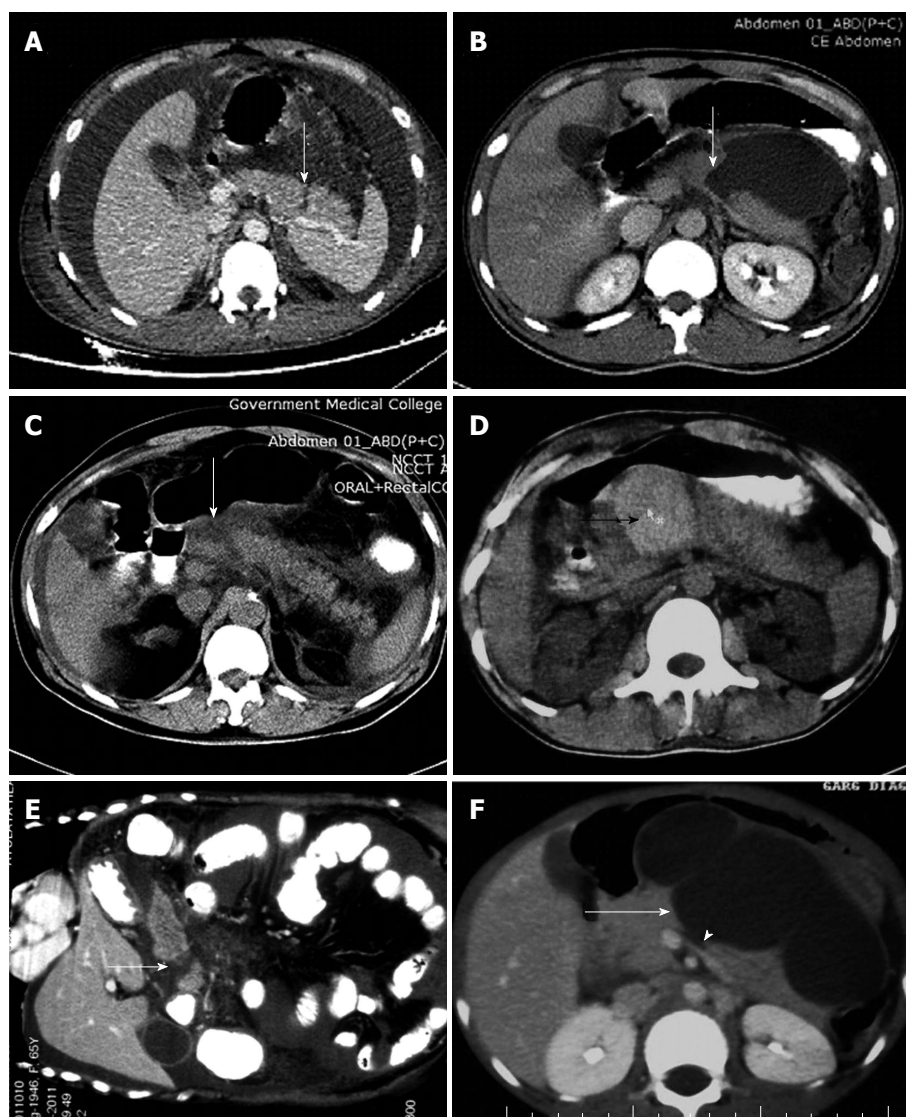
Computed tomography images.
